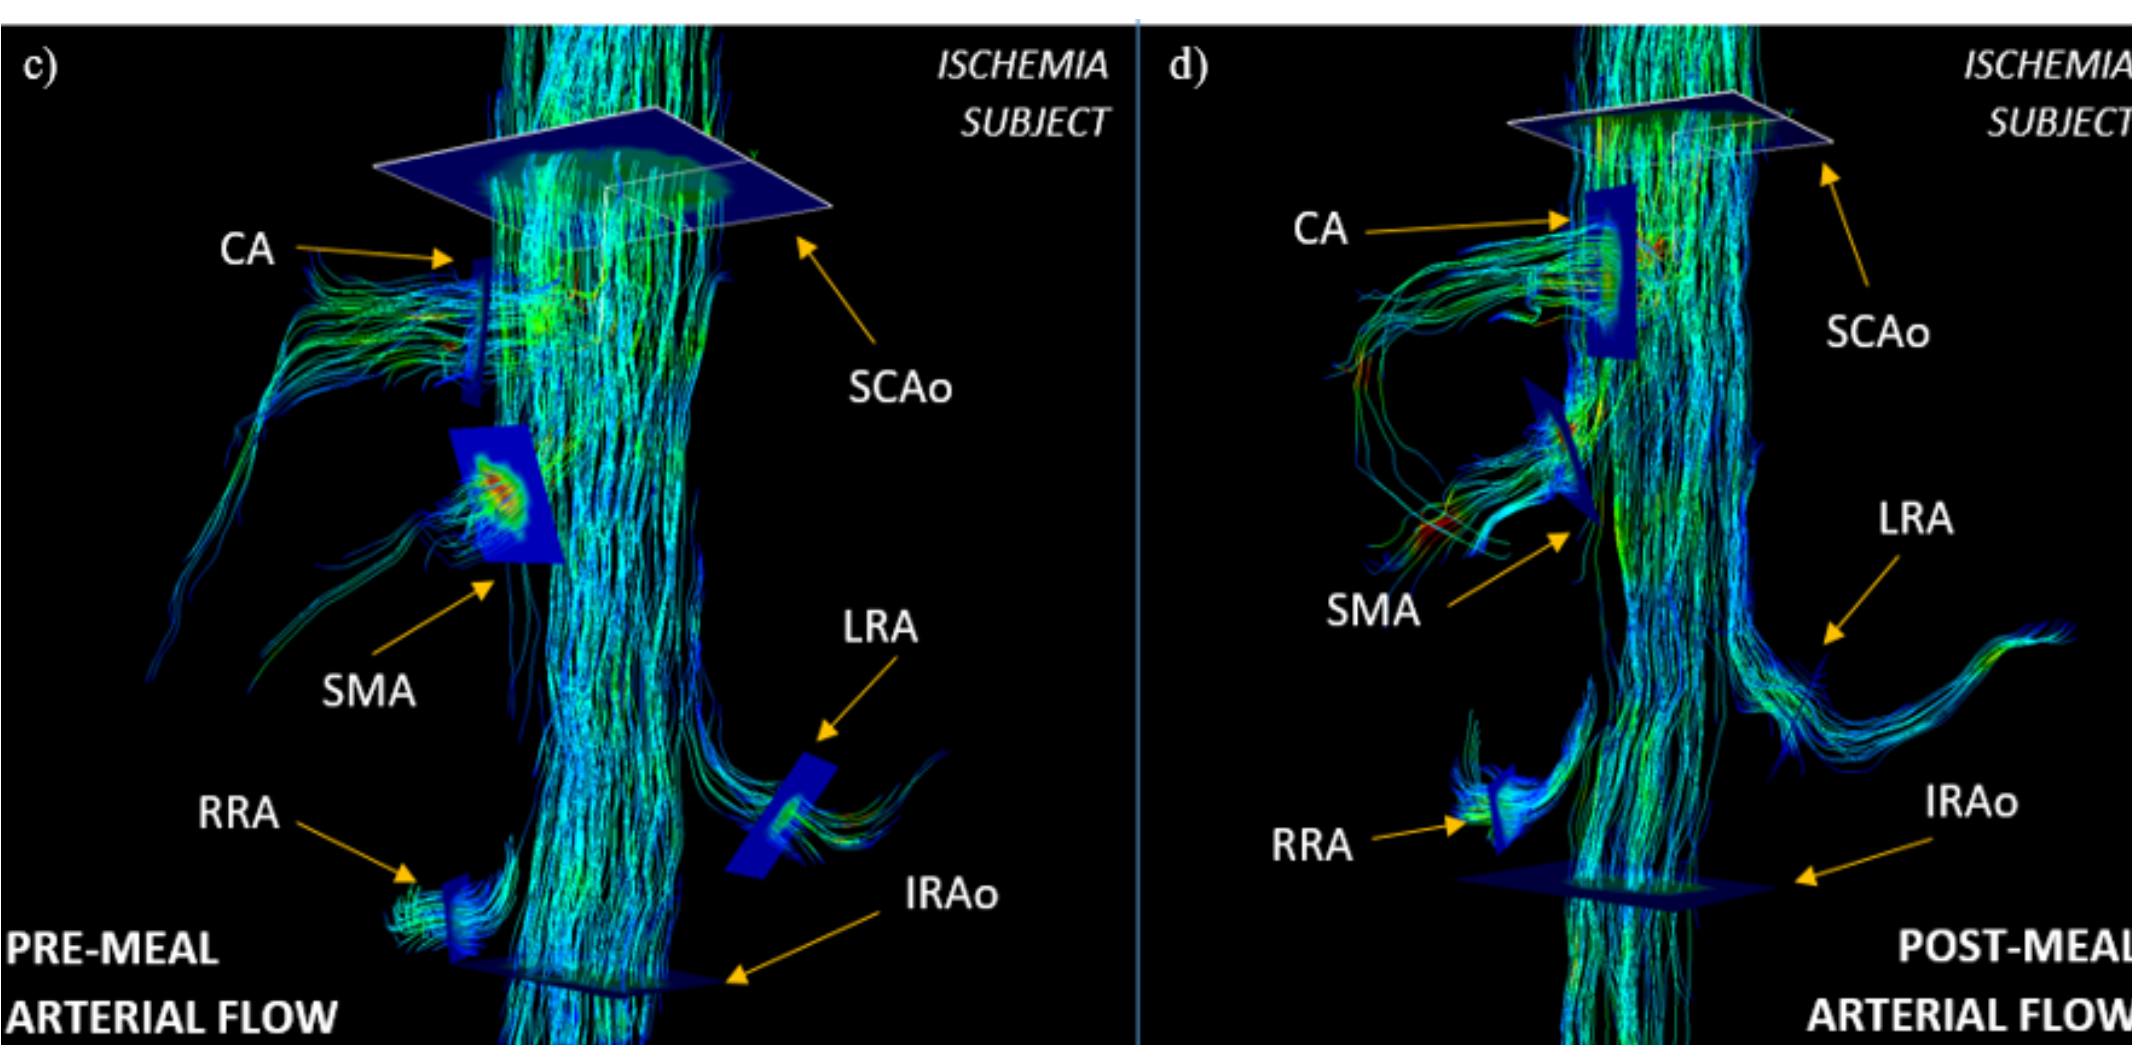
4D arterial flow MRI streamline images for a control subject (figures a and b) and an ischemia subject (figures c and d) both before (figures a and c) and after a meal challenge (figures b and d)
